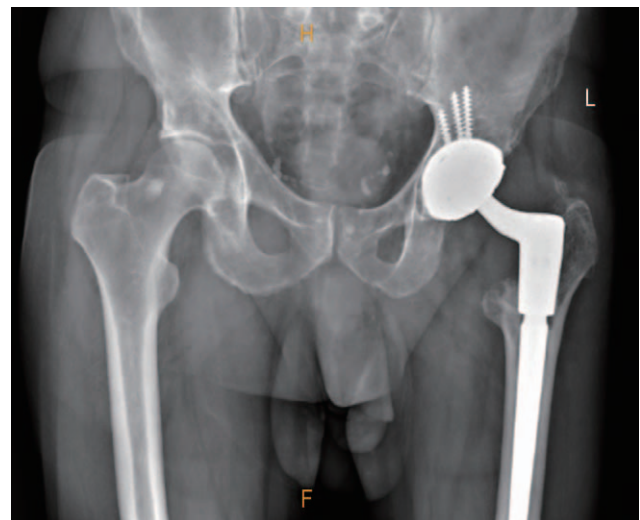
Anteroposterior pelvis x-ray at 1-year follow-up. The definitive implants include Stryker Trident[®] Tritanium[®] shell with 3 screws, Restoration[®] MDM[®] X3[®] polyethylene insert, Restoration[®] Modular Hip System femoral components, Biolox[®] delta 28 mm ceramic head.
